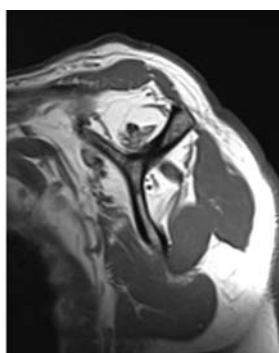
Fatty infiltration stage 4 of infra spinatus on CT scan and MRI.
